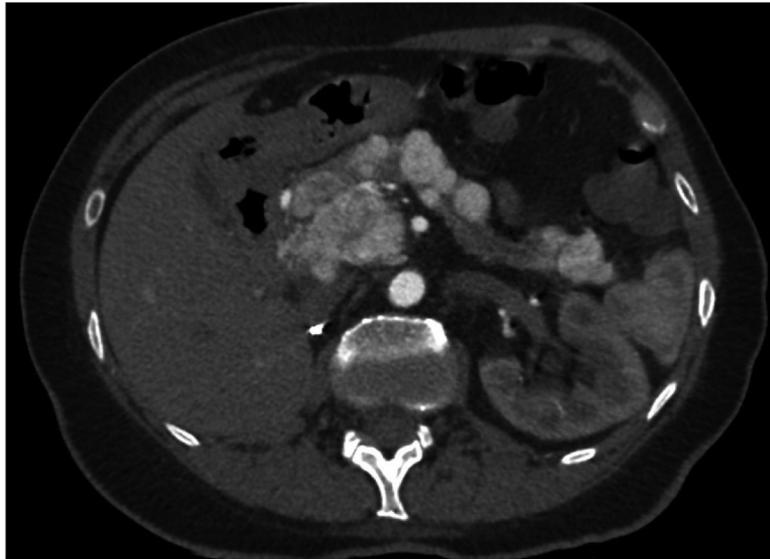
Pancreatic metastases from renal cell carcinoma in a 68-year-old female patient. Contrast-enhanced CT image obtained during arterial phase shows multiple hyperattenuating lesions within the pancreatic parenchyma consistent with pancreatic metastases. The patient had a history of right nephrectomy for renal cell carcinoma 5 years before.
